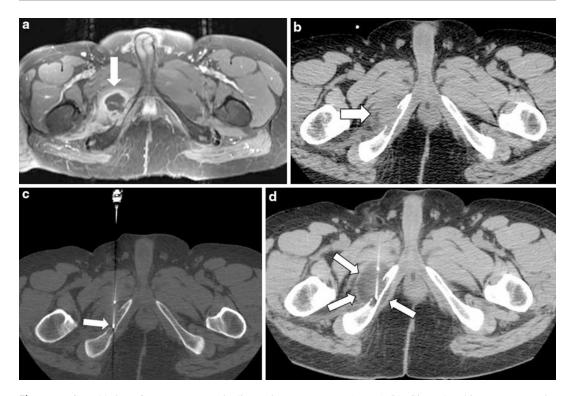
Cryoablation of osseous metastatic disease in a patient with metastatic chordoma. T1 post-contrast MR image of the pelvis demonstrates an osseous tumor with a rim-enhancing soft tissue component (*arrow*) (a). CT image (b) redemonstrates the tumor, with a lytic osseous
